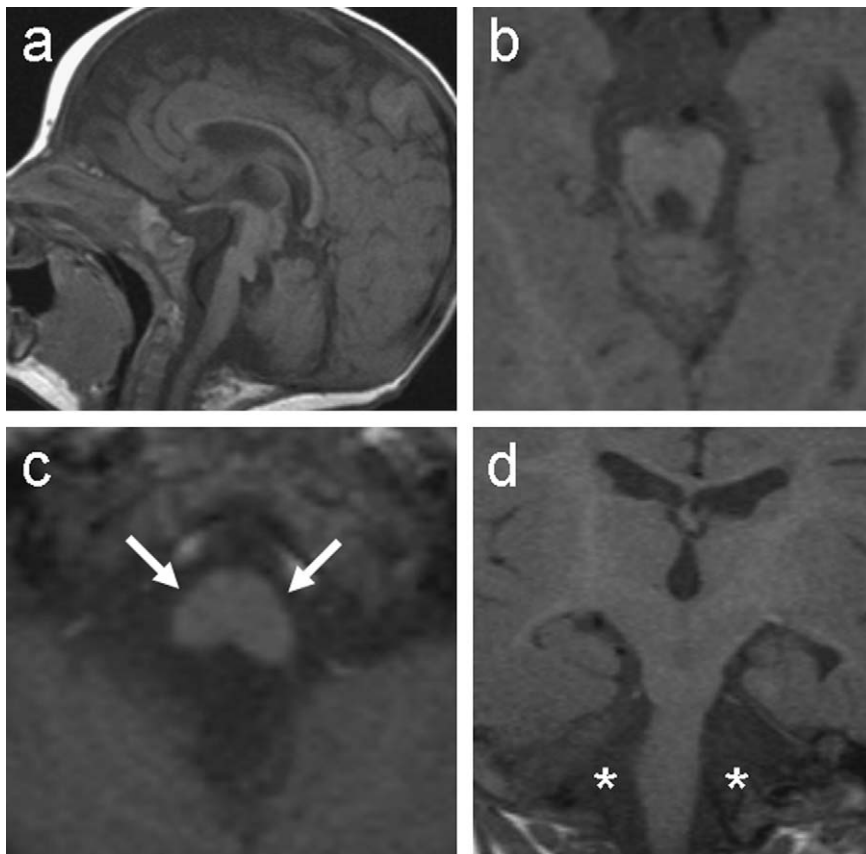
MRI of patient 1 at 6 months. a Midsagittal T₁-weighted MRI showing the flat profile of the ventral side of the pons, the vaulted structure protruding into the fourth ventricle, shortening of the mesencephalic isthmus, and dysplastic superior vermis. b Axial T₁-weighted MRI revealing abnormal shape of the superior cerebellar peduncles producing a “molar tooth” appearance. c Axial T₁-weighted MRI at the level of the medulla oblongata demonstrating the absence of the contours of the inferior olivary nuclei (arrows). d Coronal T₁-weighted MRI showing the absence of both middle cerebellar peduncles (asterisks), slightly enlarged lateral ventricles, and dysplastic hippocampi with reduced inrolling.
